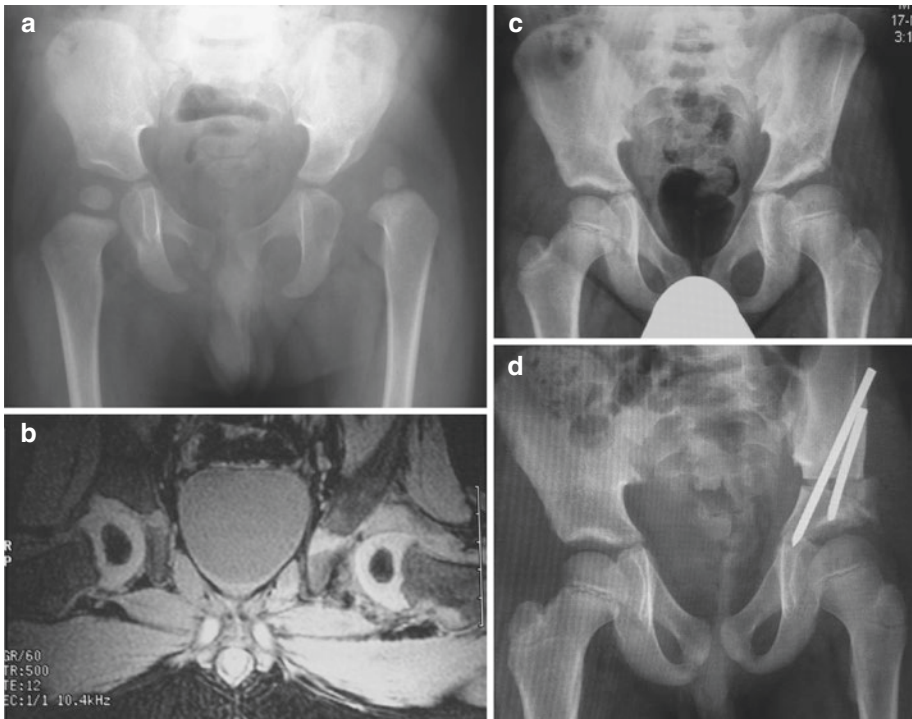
Salter osteotomy. (a) 15 month-old boy with a dislocated left hip and severe acetabular dysplasia. (b) Axial MRI scan showing concentric reduction of the left hip post medial open approach. (c) Persistent acetabular
